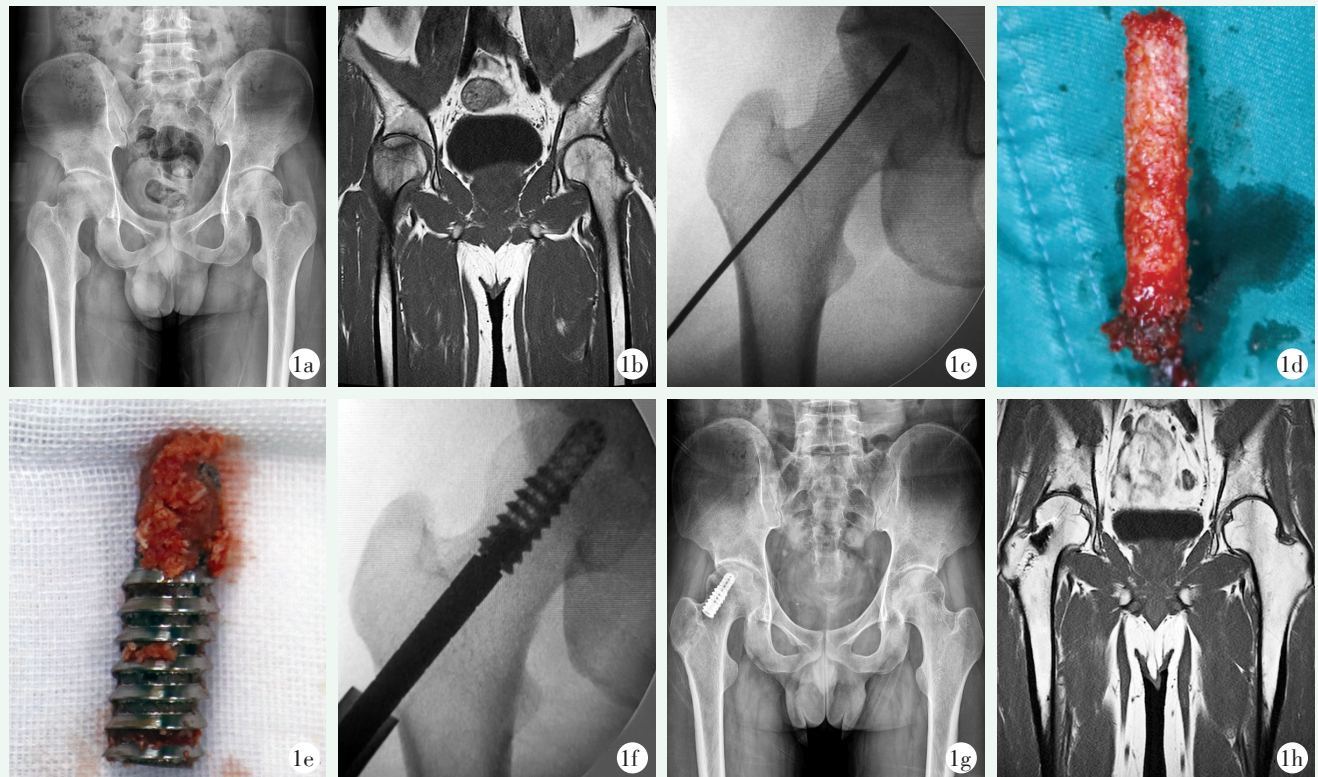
患者男性, 21 岁。1a: 术前髋关节正位 X 线片示右侧股骨头负重区密度不均; 1b: 术前 MRI 示右侧股骨头负重区信号改变; 1c: 术中导针透视定位, 位置满意; 1d: 环锯钻取松质骨骨条; 1e: 多孔钛笼架内填充松质骨; 1f: 术中透视见多孔钛笼架置入股骨头内, 位置满意; 1g: 术后 12 月髋关节正位 X 线片可见多孔钛笼架位置满意, 软骨下骨支撑良好, 右侧股骨头形态良好, 坏死区无进展, 骨隧道愈合良好; 1h: 术后 12 个月髋关节 MRI 示股骨头形态良好, 多孔钛笼架在位, 原坏死区信号较术前明显改善。
